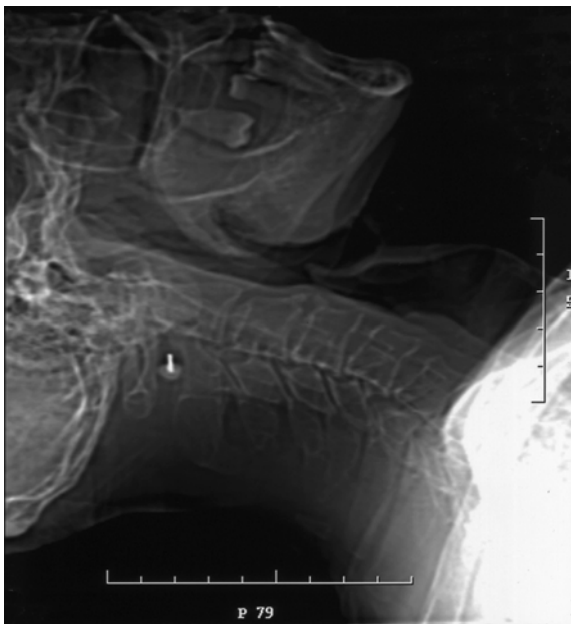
Lateral radiograph of percutaneous cordotomy
